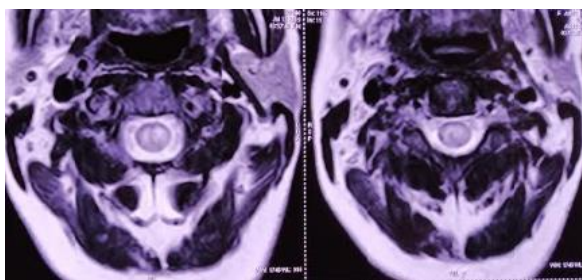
MRI spine T2 axial sections showing central intramedullary hyperintensity.
